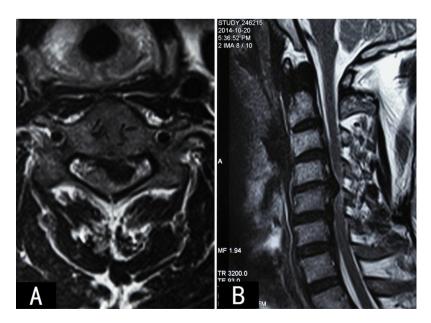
Cervical MRI. The herniated C4-C5 disc compressed left side of the spinal cord (A), consistent to the weakness in left limb and sensory deficit in the ride side. Increased signal intensity on T2 weighted image (B) indicated severe spinal cord injury, which may lead to poor prognosis.
